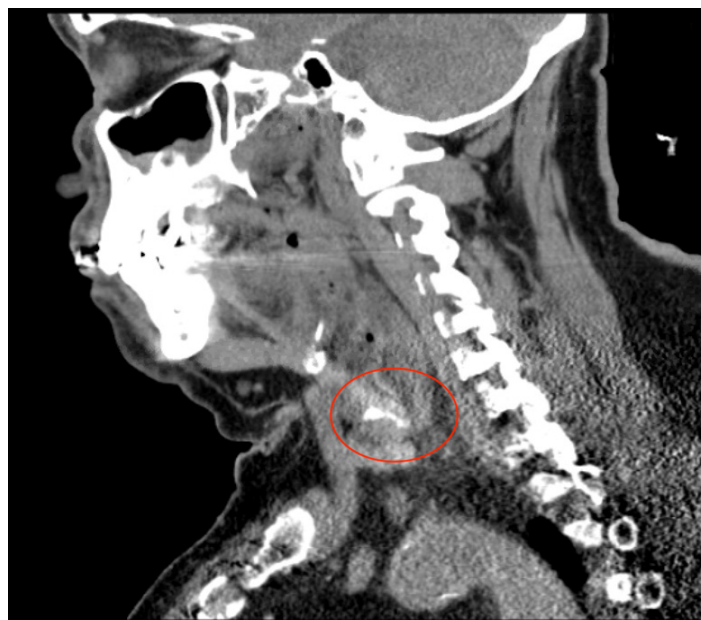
Sagittal computer tomography (CT) scan of the swallowed dental bridge.
